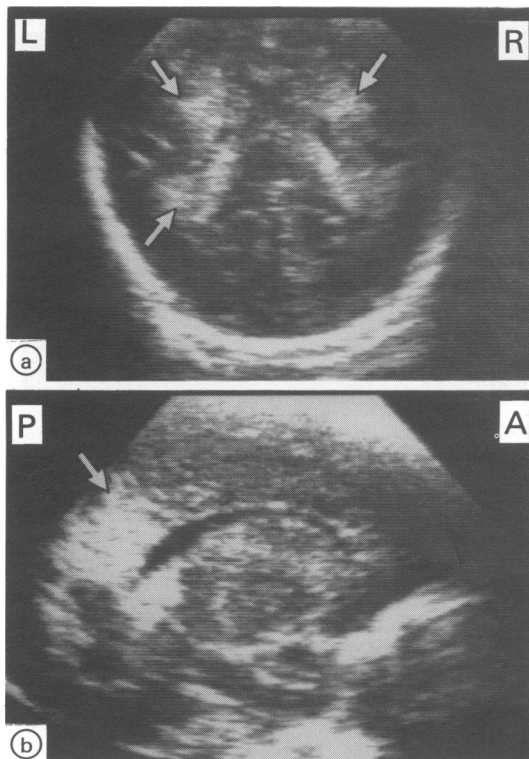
Case 3, gestational age 31 weeks. Ultrasound scan showing periventricular densities on day 1. Semiaxial scan (a); parasagittal scan (b).
